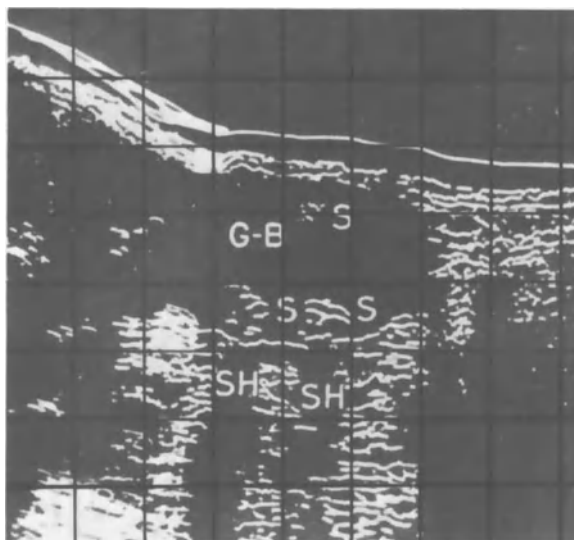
Ultrasonography: Longitudinal B-scan of the gallbladder (GB) showing cholecystolithiasis (S). Echo free bands - acoustical shadows (SH) are seen posterior to the gallstones. (Ronský.)
